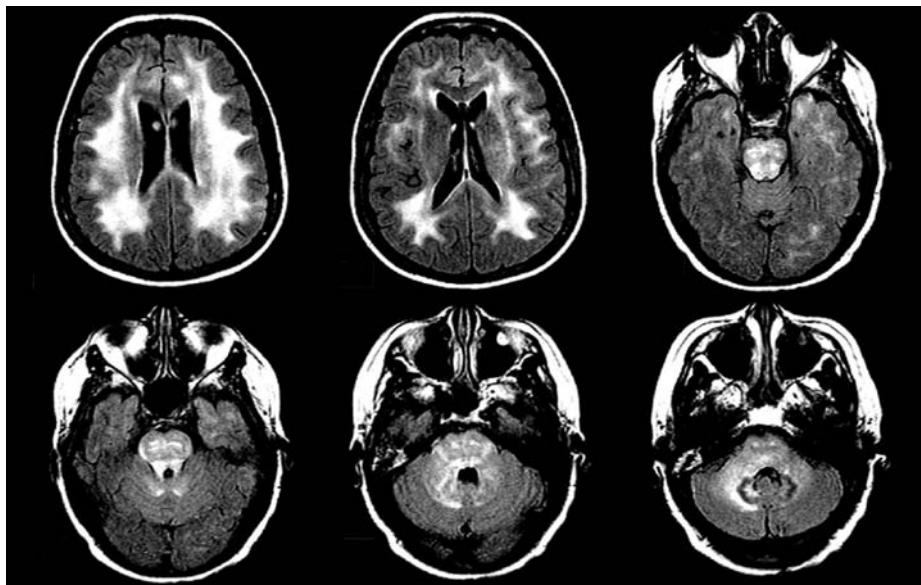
MR imaging of gliomatosis cerebri, as seen on FLAIR sequences, reveals the characteristically extensive involvement of the central nervous system, which, in this case, includes the cerebral hemispheres bilaterally, the brain stem, and the cerebellum.
